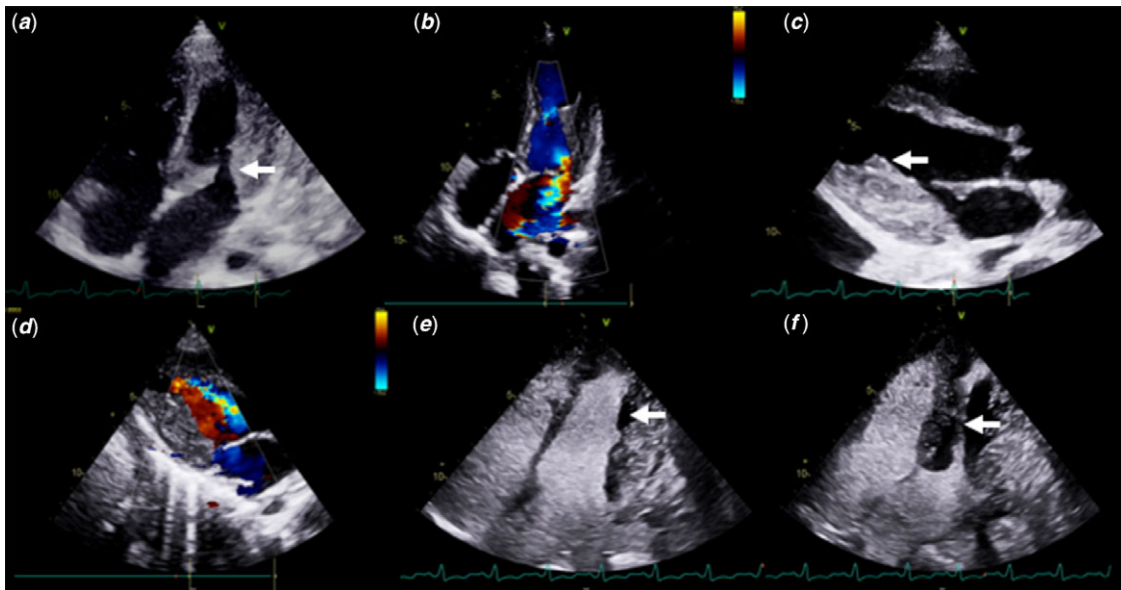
Transthoracic echocardiography with accompanying left ventricle (LV) contrast sequence demonstrating endomyocardial fibrosis, LV mural thrombus and severe mitral regurgitation (MR). (a) apical four chamber view shows LV hypertrophy primarily involving posterior wall, posterior mitral leaflet plastered to posterior wall (solid white arrow), right atrium, and right ventricle are dilated. (b) Corresponding view with colour flow shows severe MR with eccentric posteriorly directed jet. (c) Parasternal long-axis view shows mural thrombus attached to LV posterior wall (solid white arrow) and involving the papillary muscles and posterior mitral leaflet. (d) Corresponding view with colour flow shows flow turbulence across LV mid-cavity due to systolic obliteration by mural thrombus. (e) LV contrast echo shows filling defect corresponding to mural thrombus seen in image (c) (solid white arrow). (f) LV contrast echo shows systolic obliteration of LV mid-cavity (solid white arrow).
